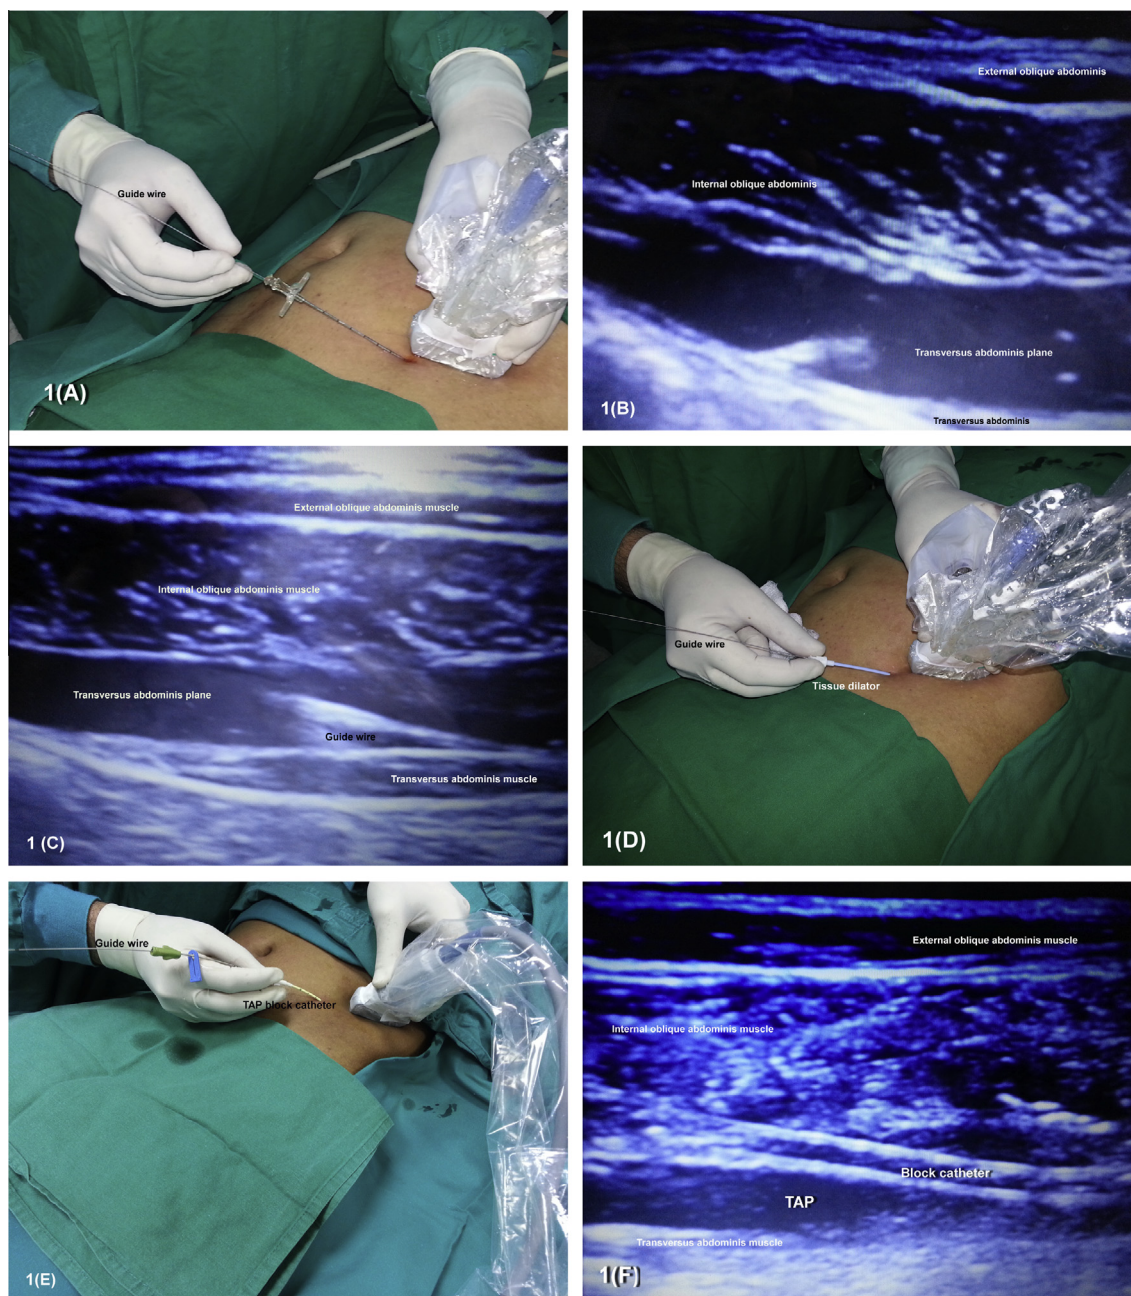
Steps of ultrasound-guided Seldinger catheter insertion approach (USCIA) and their corresponding ultrasound images. (A) Tuohy needle was inserted into the transversus abdominis plane and the guide wire was passed through the needle. (B) Expansion of transversus abdominis plane as a dark shadow after saline injection. (C) Advancement of guide wire within the transversus abdominis plane. (D) Tissue dilator was passed over the guide wire. (E) Block catheter was passed over the guide wire. (F) Advancement of the block catheter into the transversus abdominis plane.
